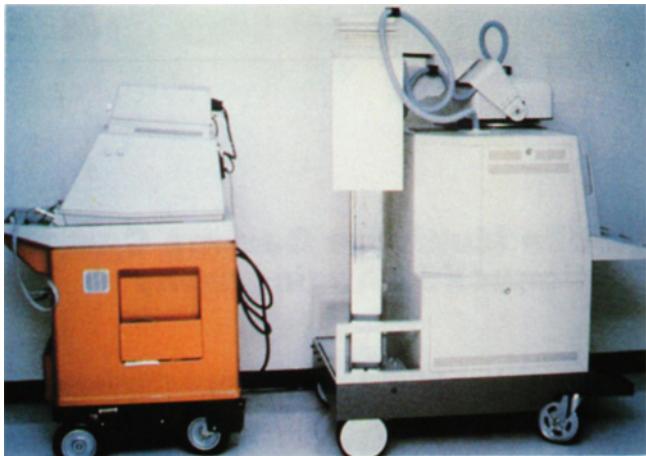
Size comparison of multiwire gamma camera (right) to echocardiography machine (left).
